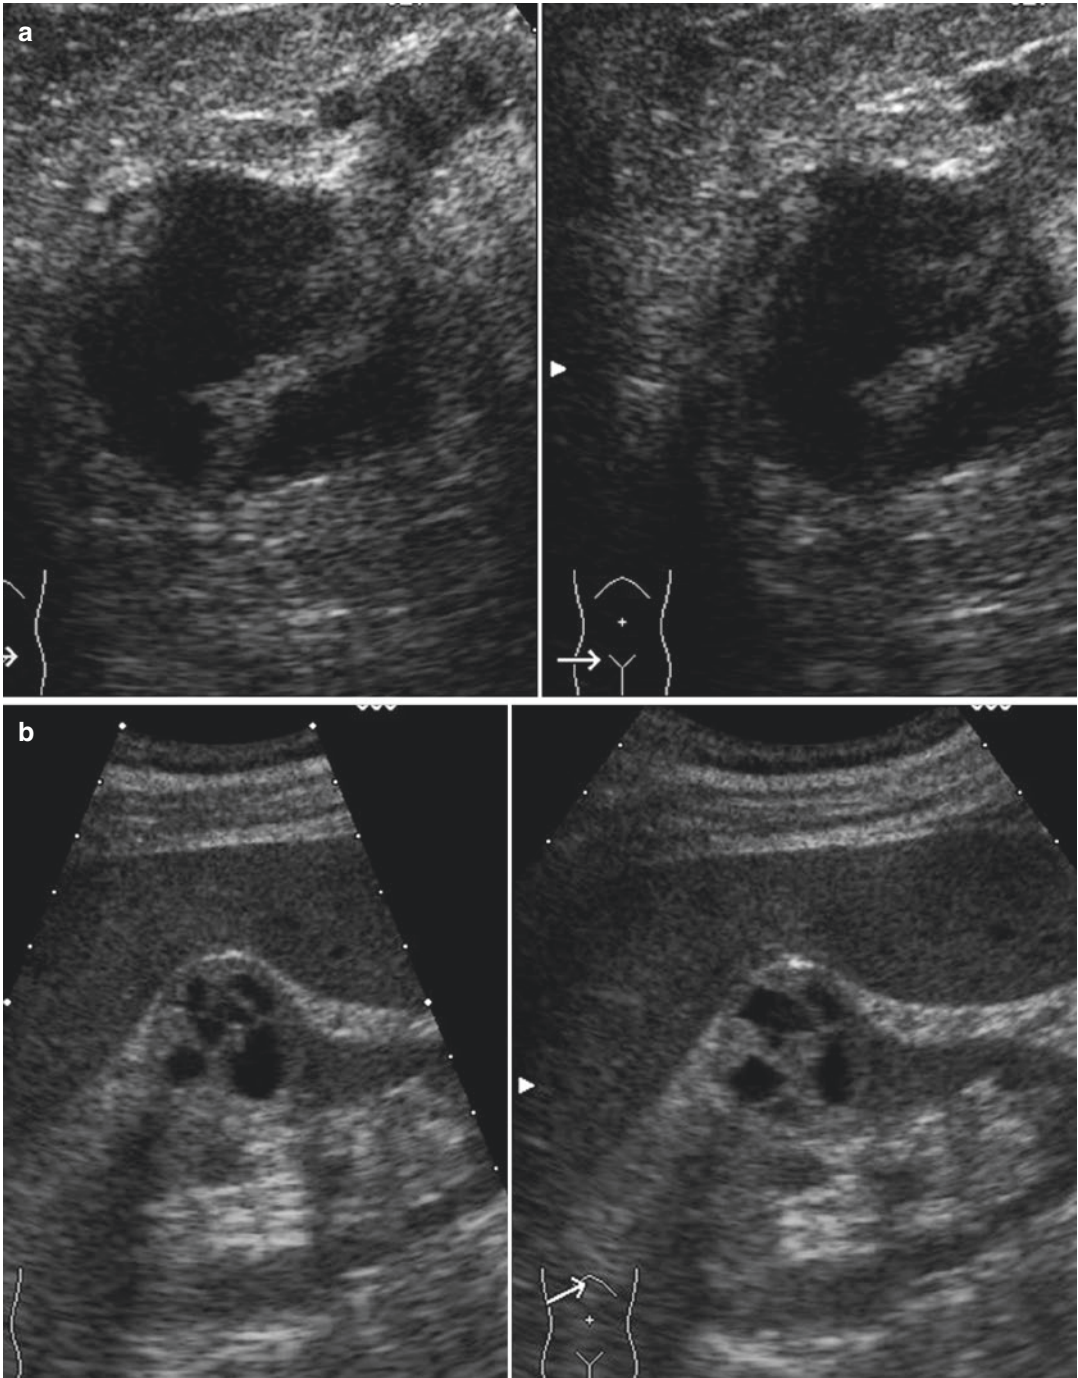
(a) Cyst with thick walls with nodular septa. (b) Cyst with thick walls and nodular and diffused septa. (c) Abundant vascularization of the walls and the septa at Doppler US. Cystic renal cell carcinoma
